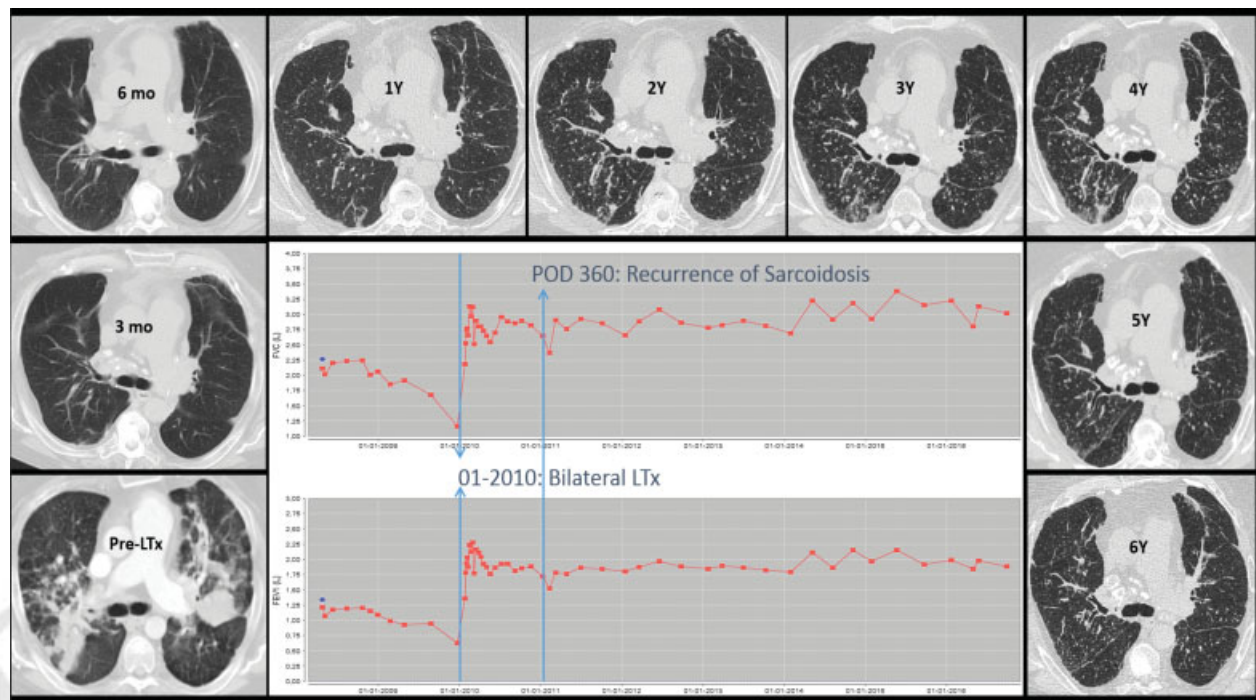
Recurrence of sarcoidosis with stable pulmonary function after bilateral lung transplantation in a 41-year-old man. Evolution of radiology (consecutive chest CTs pretransplant, at 3, 6 months, and 1–6 years posttransplant) and of pulmonary function (forced vital capacity, L, top and forced expiratory volume in 1 second, L, bottom) over time after bilateral LTx for sarcoidosis in a 41-year-old man. Recurrence of sarcoidosis, despite maintenance treatment with methylprednisolone, cyclosporine (later tacrolimus), and azathioprine was diagnosed on POD 360 by means of CT, demonstrating micronodules in upper lobes and transbronchial biopsies, demonstrating the presence of noncaseating granulomas. Over time after transplantation bilateral pleural thickening, diffuse centrilobular, and fissural micronodules (i.e., typical perilymphatic distribution) were evident, despite which pulmonary function remained stable. CT, computed tomography; LTx, lung transplantation; POD, postoperative day.
